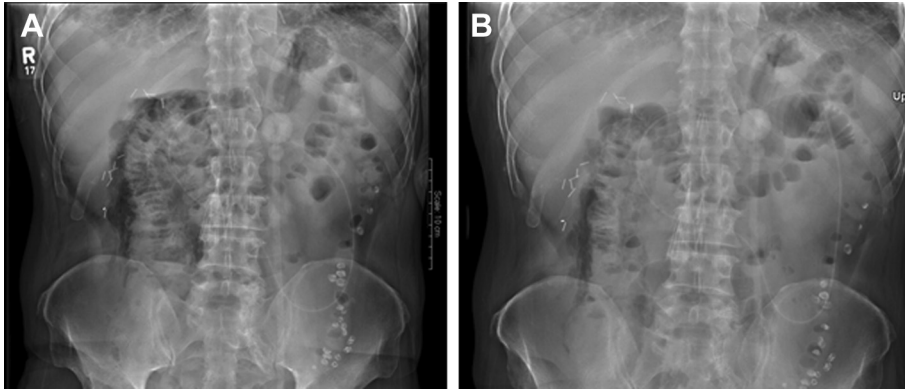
Abdominal radiographic image demonstrating persistent abnormal gas patterns along the descending and transverse colon.
